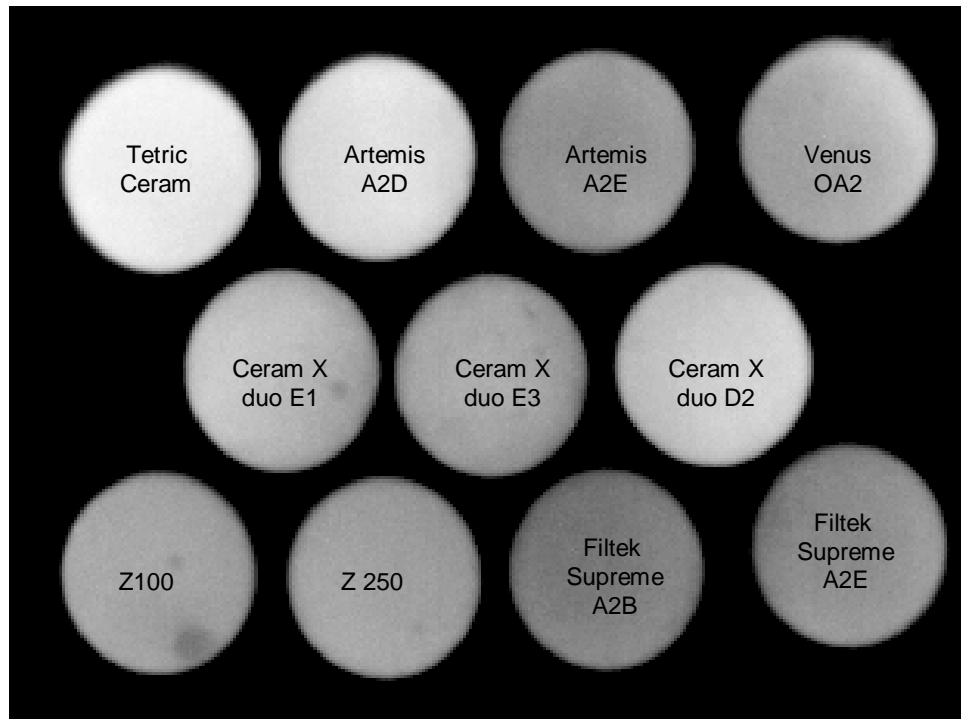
Radiograph of 2mm thick samples to compare radiopacity
